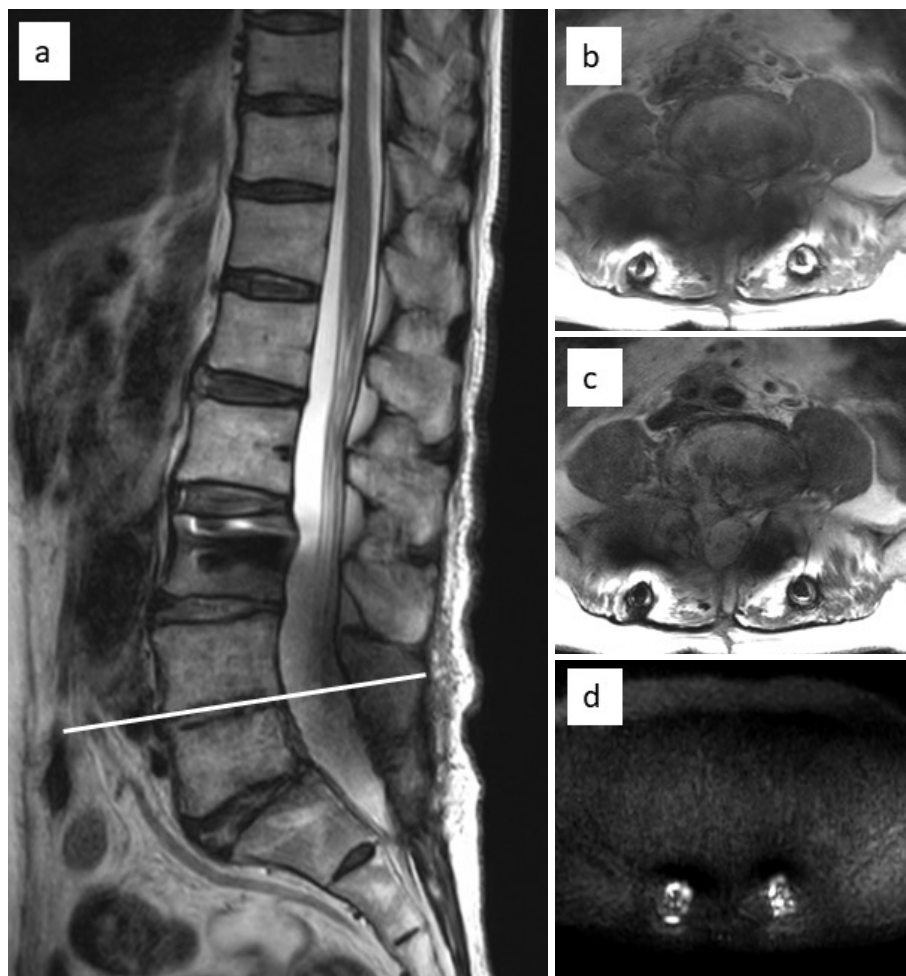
(a) Magnetic resonance imaging with T2 sagittal, (b) magnetic resonance imaging with T1 coronal, (c) magnetic resonance imaging with T2 coronal, (d) magnetic resonance imaging with a diffusion-weighted image (DWI). Magnetic resonance imaging showing no signal change in the area where FDG-PTE/CT accumulated FDG.
